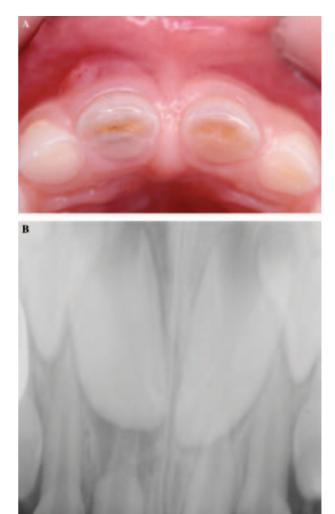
Maxillary primary central incisors with dark coronal discoloration. (A) Attrition of the right incisor till exposure of the pulp, infection and development of sinus tract. (B) Radiograph showing inflammatory root resorption.
